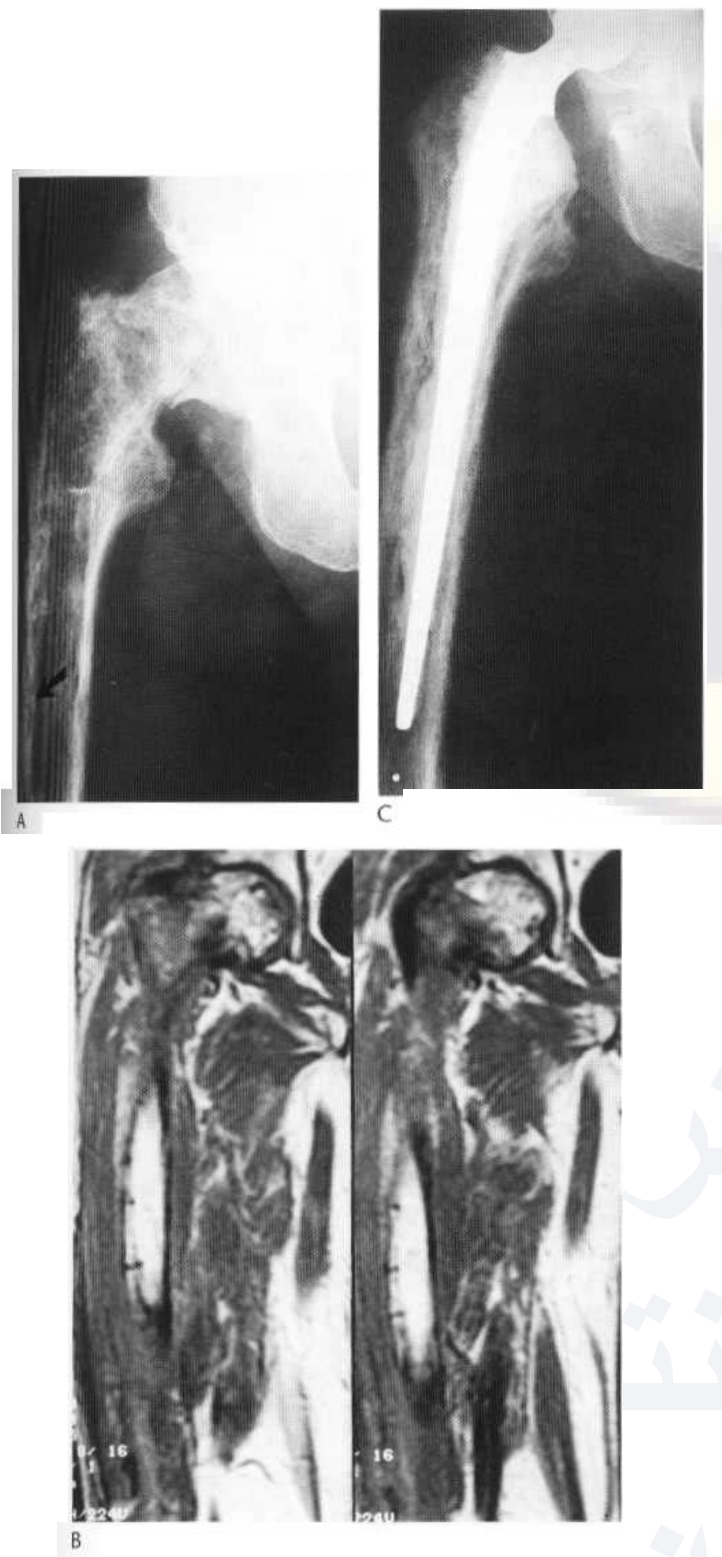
Pathological and insufficiency fractures in Paget's disease. (A) The proximal femur shows all the changes of Paget's disease and a transcervical fracture has occurred. A transverse insufficiency fracture (arrow) is shown in the lateral femoral cortex. (B) Coronal T₁-weighted MR images of the right femur demonstrate changes related to the fracture of the femoral neck—there is varus deformity and quite marked alteration of fatty marrow signal due to haemorrhage. In addition, multiple insufficiency fractures are demonstrated in the lateral femoral cortex. (C) The insufficiency fractures are very well seen in the postoperative film.
